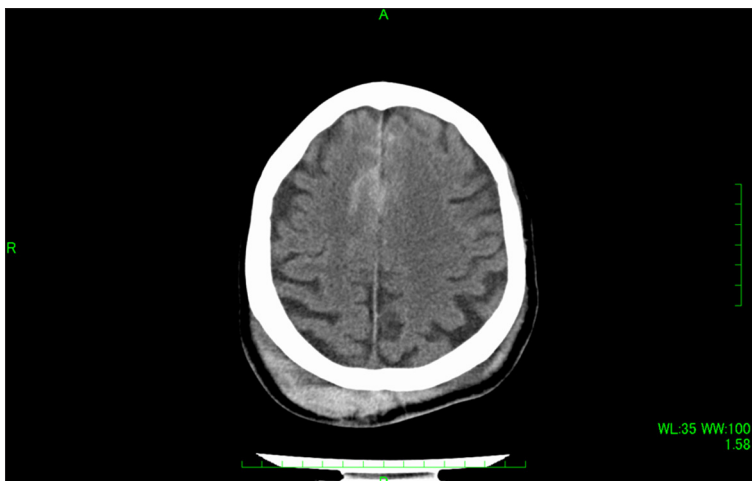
Initial head CT scan showed subarachnoid hemorrhage and small contusion.
